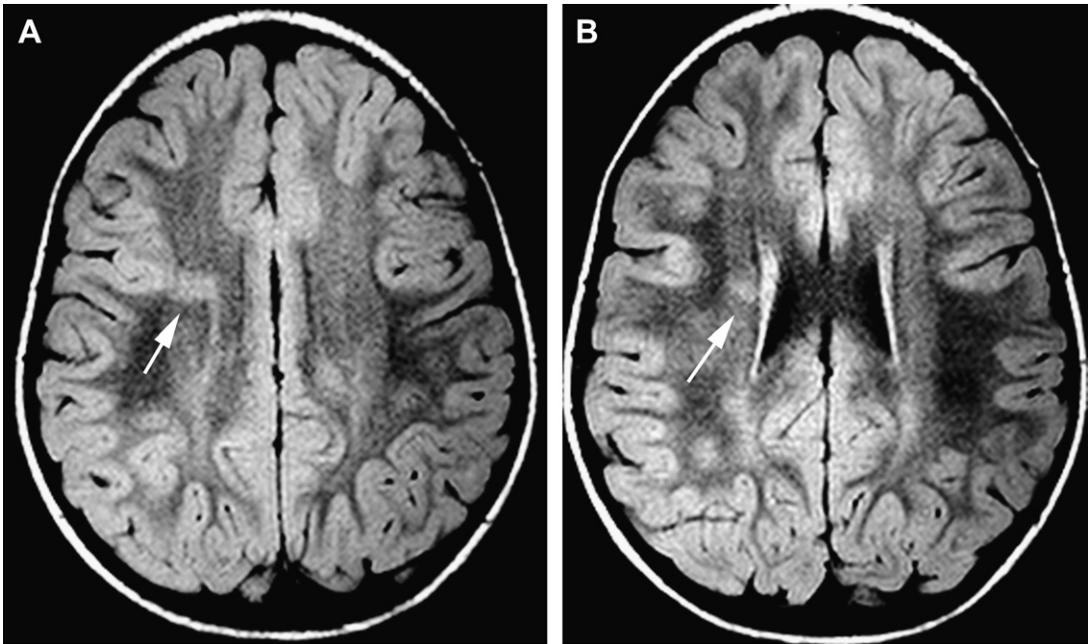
Transmantle dysplasia (FCD IIB). (A, B) Axial FLAIR. There is cortico-subcortical blurring of the right precentral cortex with a streak of high FLAIR signal extending from the depth of the sulcus to the ventricular wall (arrow). This pattern is practically pathognomonic for FCD IIB (with balloon cells).
